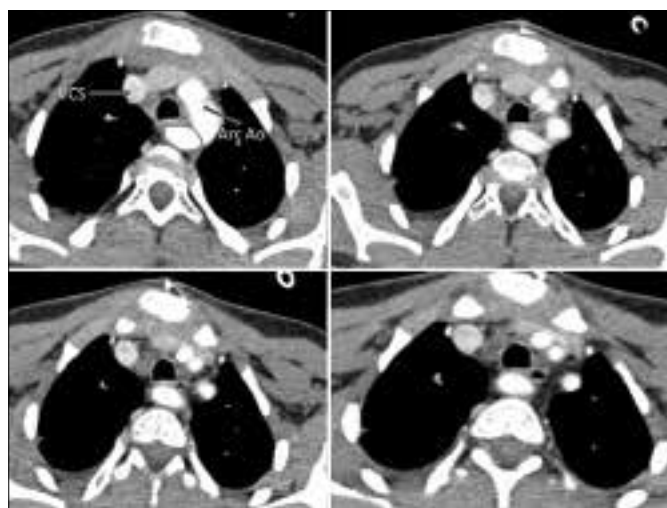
Computed tomographic angiography image an aberrant right subclavian artery. Right aberrant subclavian artery circled in red.
